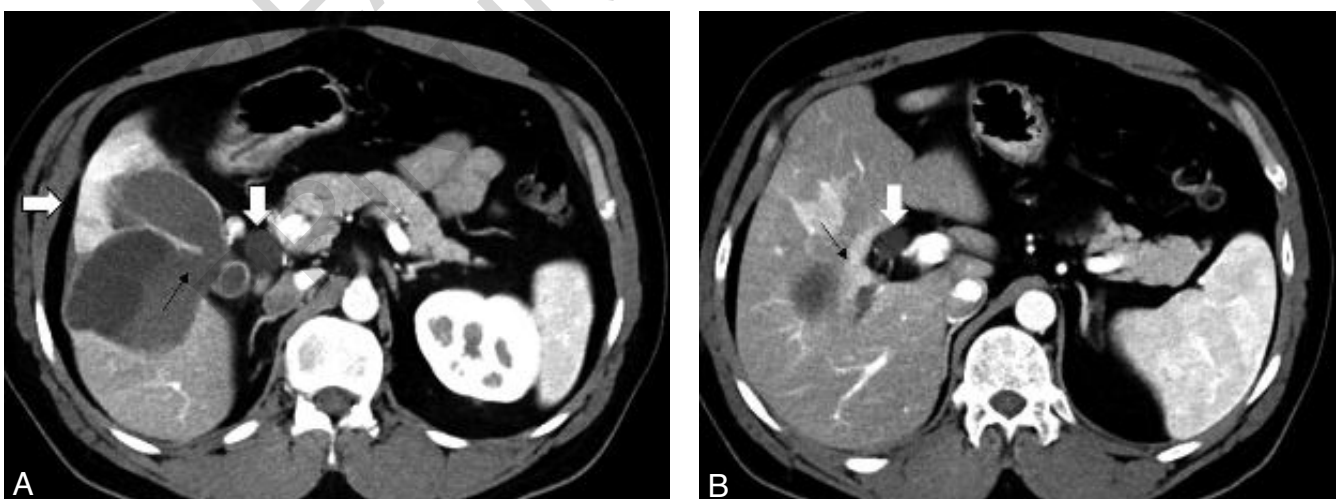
Contrast –enhanced CT images taken in portal phase. A) the close relationship of the gall bladder and the hydatid cyst and the loss of integrity in the medial wall of the neck of the gall bladder (thin black line). The enhanced contrast uptake due to inflammation in segment five of the liver was shown with thick white arrow. Additionally, there is increased contrast uptake in the gall bladder and cystic canal's wall; B) The hydatid cyst opens into posterior segment biliary tract and there is increased contrast enhancement due to cholangitis in liver parenchyma in that region (thin black arrow). Dilated common bile duct is shown by thick white arrows.
